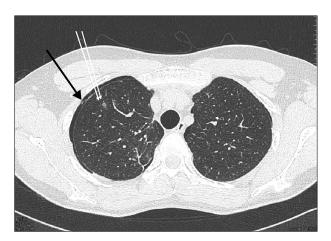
Chest high-resolution computed tomography (HRCT) of patient 2. A single arrow indicates the newly developed bulla, and a double arrow shows the cavitary nodule in the right upper lobe, which was not identified on the previous HRCT conducted 4 months earlier. A small amount of pneumothorax with pleural effusion was also noted.
